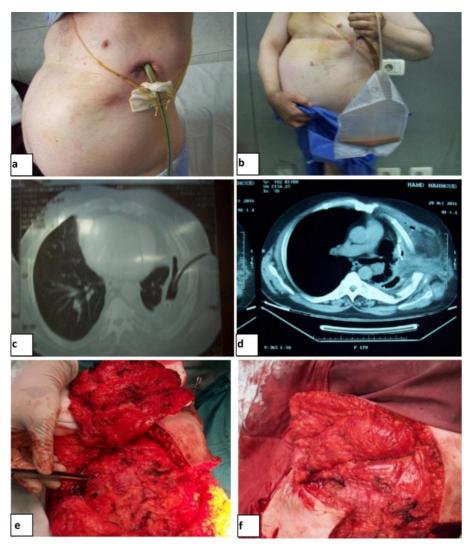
A patient with post lobectomy empyema with no bronchopleural fistula: (a& b) Preoperative pictures showing infected discharge,(c) CT chest (axial view) showing calcified wall of empyema cavity, (d)Intrathoracic transposed muscle in place, (e) Intraoperative pictures showing latissimusdorsi flap, (f)Intrathoracic muscle transposition.
